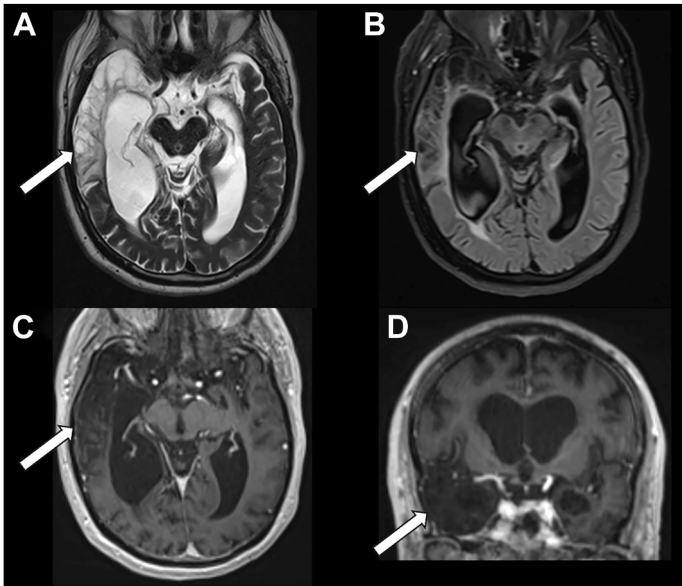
Sequela of HSV encephalitis involving the optical radiations within the right temporal lobe. Axial T2-weighted (A), axial FLAIR (B), axial postcontrast T1 (C–D), and coronal postcontrast T1 showing encephalomalacia (white arrows) involving the right temporal lobe, including portions of the optical radiations (Meyer's Loop) in a patient with sequela of HSV encephalitis. HSV, Herpes Simplex Virus.
